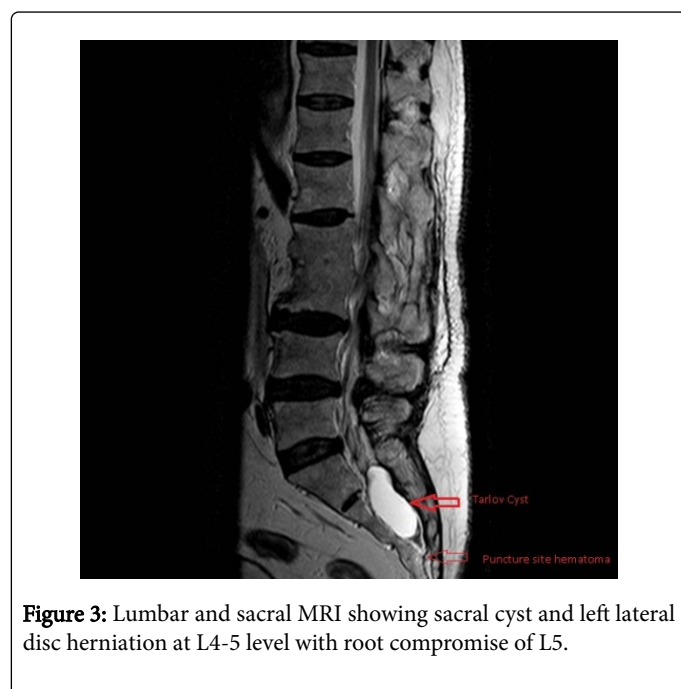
Lumbar and sacral MRI showing sacral cyst and left lateral disc herniation at L4-5 level with root compromise of L5.
